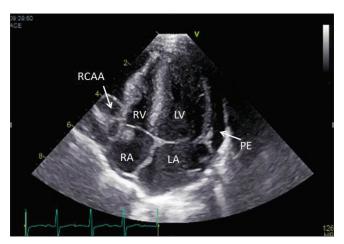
Apical 4-C view is showing the moderate amount of pericardial effusion around the heart (arrow) and a giant aneurysm of distal right coronary artery (arrow). RA: right atrium, RV: right ventricle, LA: left atrium, LV: left ventricle, PE: pericardial effusion, RCAA: right coronary arterial aneurysm
